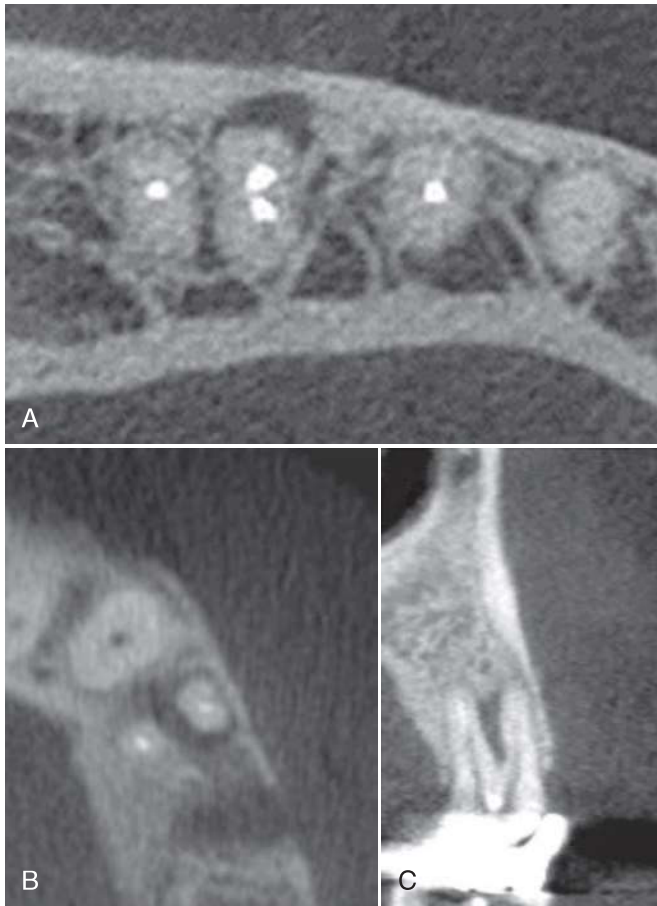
“Invisible” bone destruction associated with early VRFs. A, Buccal VRF was present in the mesial root of a first left mandibular molar. At this early stage a typical VRF pocket was evident, yet no associated bone destruction was observed in a periapical radiograph. The VRF-associated bone destruction was evident in an axial plane of a CBCT. B, A VRF was present in the palatal side of the buccal root of the first maxillary premolar. A draining sinus tract was present with no radiographic signs to explain it. C, CBCT revealed a radiolucent lesion on the palatal side of the buccal root, which was verified, after extraction, as caused by VRF. Please note that in neither of these cases could the actual VRF fracture line be seen in the CBCT scan. (*B*, Courtesy Dr. Anda Kfir, Tel Aviv.)
